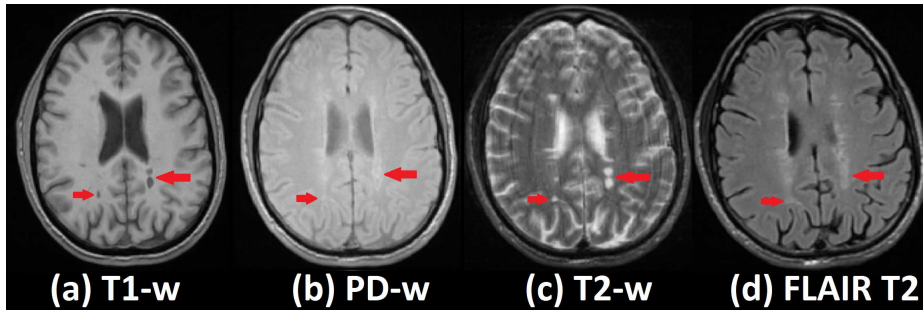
(a) T1-w, (b) *PD*-w, (c) T2-w, and (d) T2-FLAIR images of a damaged brain. *MS* lesions are pointed at by red arrows.
